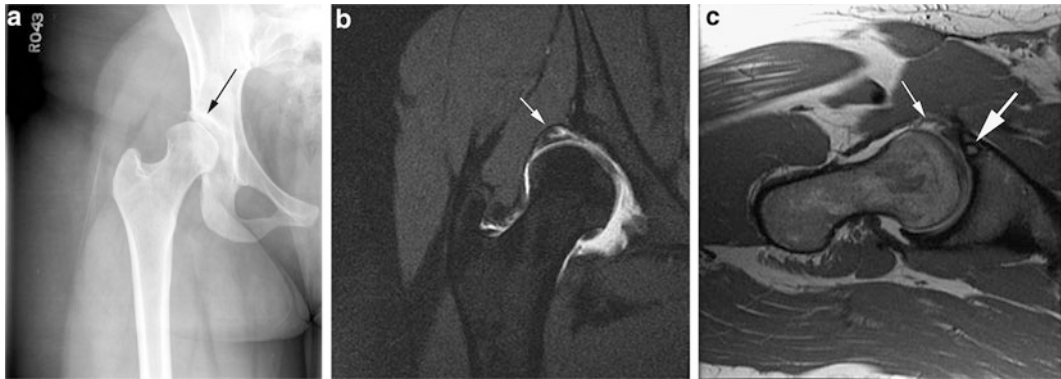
Developmental hip dysplasia. (a) Radiographs showing a shallow acetabulum (*black arrow*) with uncovering of the femoral head. (b) Hypertrophied and torn labrum (*white arrow*), with incongruence of the femoral head within the acetabulum. (c) Subchondral cysts are
